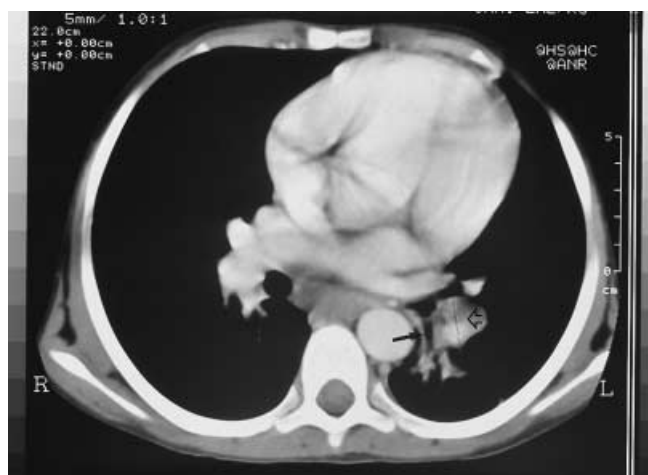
Axial contrast-enhanced CT shows a left lower lobe bronchus (*closed arrow*) leading to the mass (*open arrow*)
